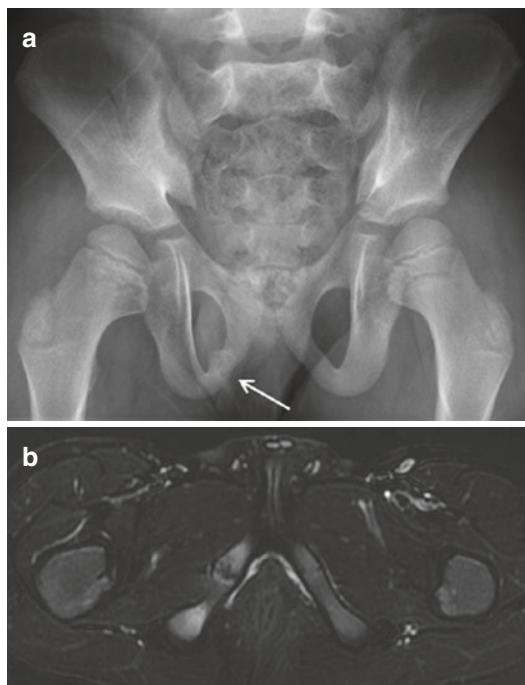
(a) Frontal pelvis radiograph of a 6-year-old boy with acute right hip pain, showing bony expansion and irregularity in the expected location of the right ischiopubic synchondrosis. This was thought to represent a normal variant. Due to ongoing pain in this area, an MRI was performed. (b) Axial T2-weighted fat-suppressed image shows marked bone marrow edema around the right ischiopubic synchondrosis, indicating a stress reaction, which is also known as ischiopubic synchondrosis syndrome, or Van Neck-Odelberg disease
